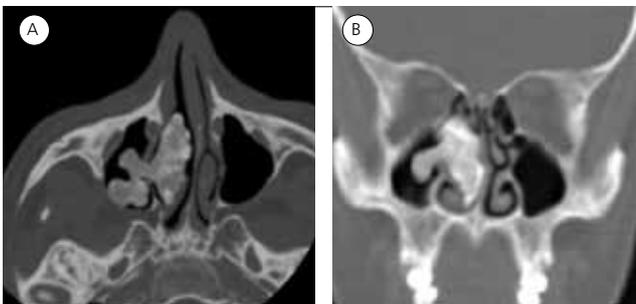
CT-scan. Axial image (A) and coronal images (B). Arrows indicate osteoma.
